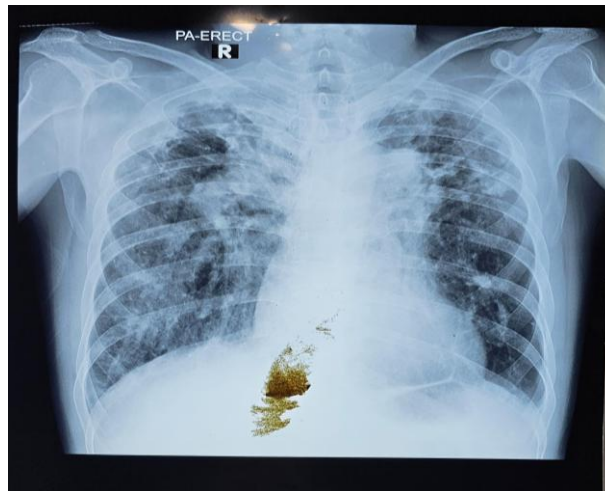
Chest X-ray showed extensive fibrosis in both lungs with emphysema
